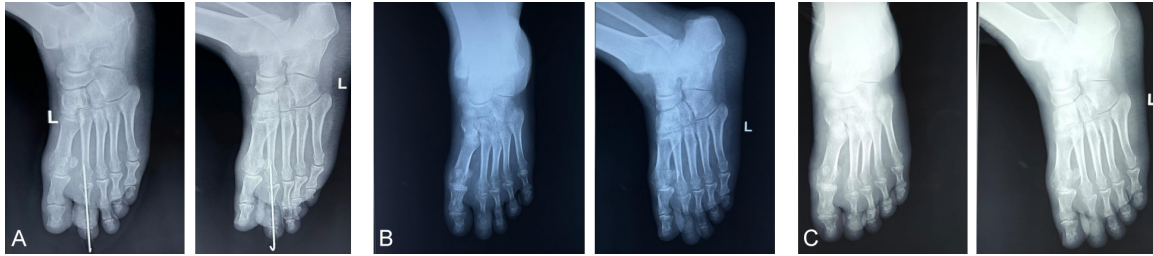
Post-operative X-ray at day 1 (A), at 6 weeks (B), at 6 months (C).
